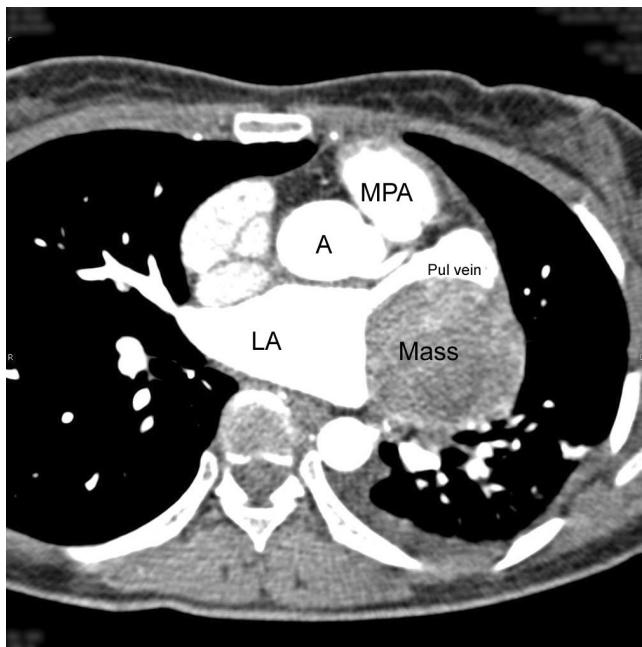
CT scan revealed the mediastinal mass. It adhered to the left atrium and compressed the left pulmonary vein.
